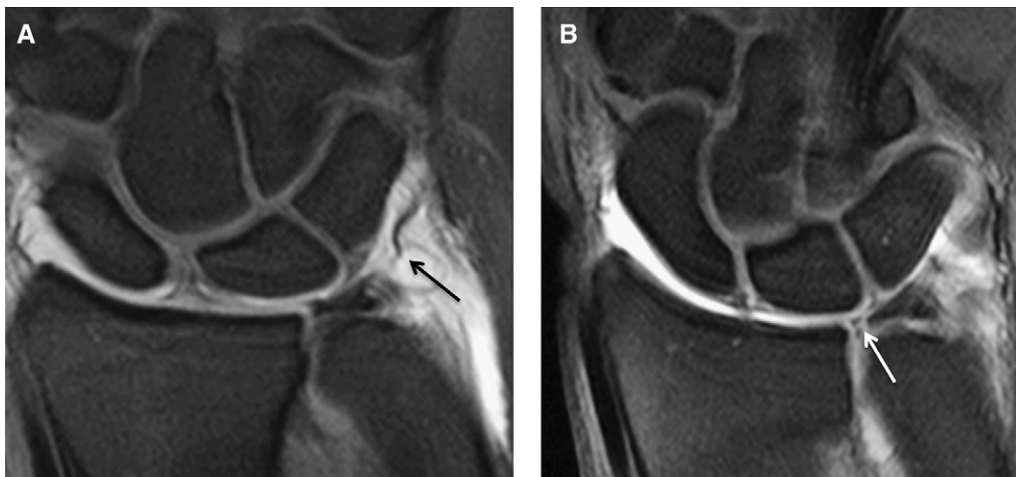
Palmer class 1C and 1D lesions. Coronal T1-weighted fat-saturated MR arthrogram images, demonstrating Palmer class 1C (A) and class 1D (B) lesions of the triangular fibrocartilage complex (TFCC). The images represent different patients. The class 1C lesion consists of avulsion of the distal attachment of the ulnocarpal and ulnolunate ligaments (black arrow), and the Palmer class 1D lesion consists of avulsion of the radial insertion of the TFCC (white arrow).
